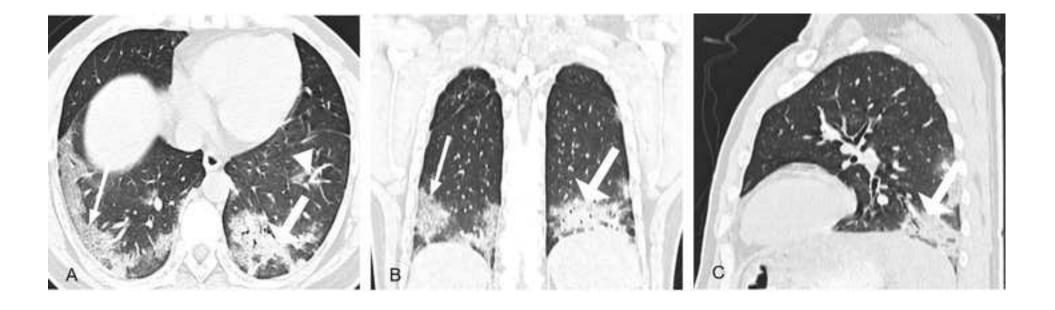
A-C, Chest CT of a 60 years old male. The clinical manifestations were
